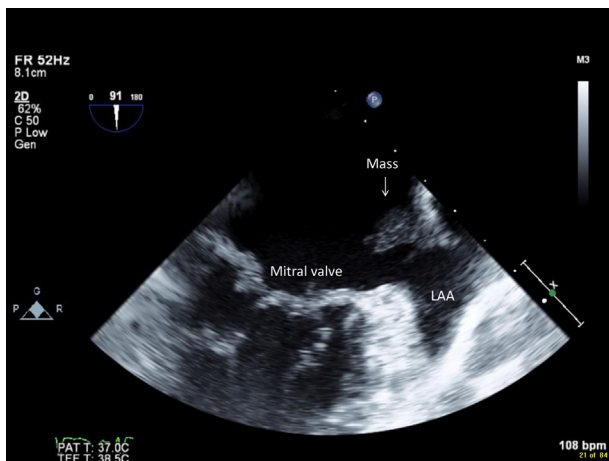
Transesophageal echocardiogram midesophageal window, commissural view showing a 1.2×1.2 cm echodensity attached to the left atrial wall just above the left atrial appendage (LAA) but not within the appendage. Also notice the thickened mitral valve leaflets.
